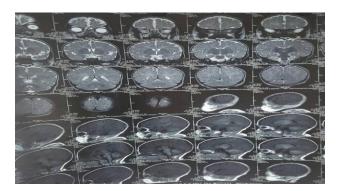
MRI brain showing pituitary adenoma scan 1.
